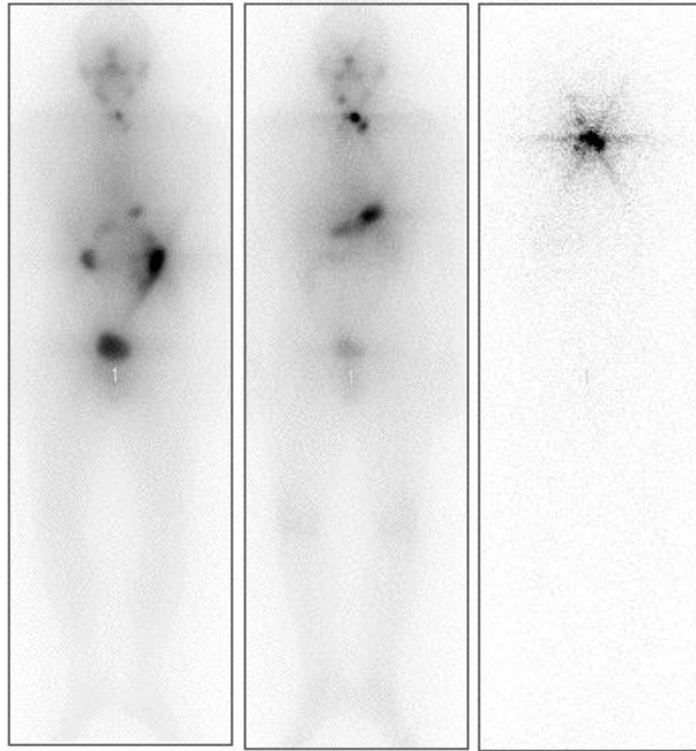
Whole-Body scan (a)2 d, (b)3.3 d, (c)8 d, after 1.1GBq ^{131}I administration showing intensely scintigraphic images.
